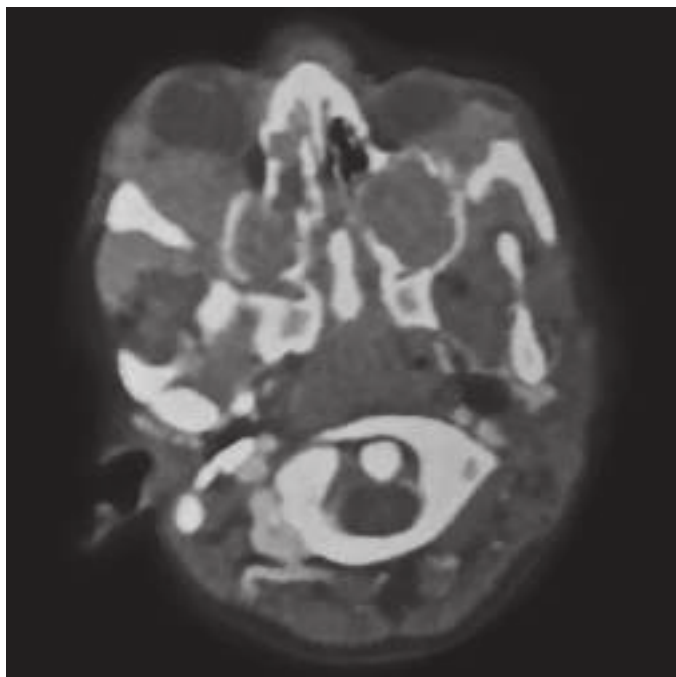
Myeloid sarcoma involving nose and paranasal sinuses on CT scan. Axial contrast enhanced computed tomography (CECT) of the nose and paranasal sinuses reveals an enhancing soft tissue mass in bilateral nasal cavities and maxillary sinus with erosion of walls of maxillary sinus, extension into ethmoid sinuses, retroconal space of bilateral orbits and premaxillary space.
